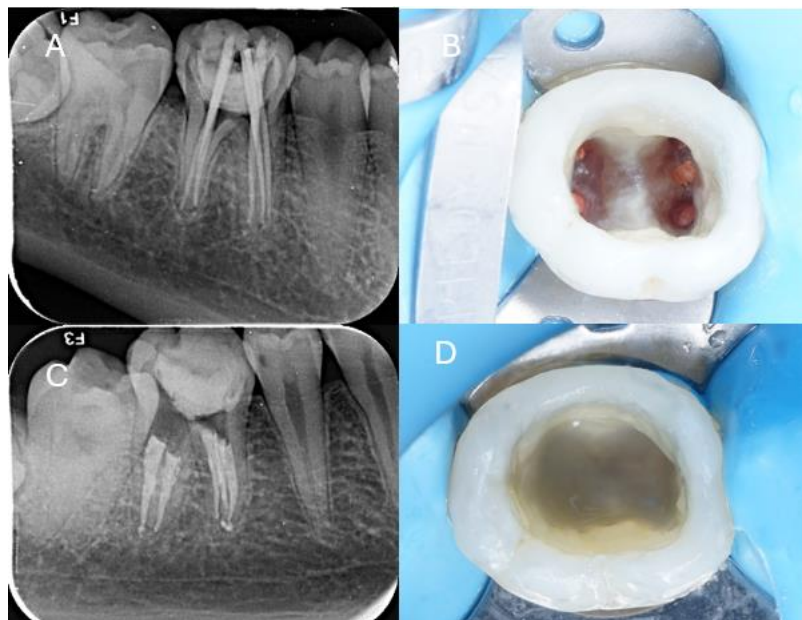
(A) Size 25 Reciproc gutta-percha cones were fitted, and periapical images using SLOB technique confirmed adaptation to the root canal shape and working length. (B) The cone was placed in the canal orifice, and vertical condensation toward the apex achieved a dense fill about 1–2 mm below the orifice using a heated endo plugger. (C) A postoperative periapical radiograph was obtained to assess the three-dimensional sealing of all canals, indicating obturation with no detected voids or overextension. (D) Smart Dentin Replacement (SDR, Dentsply Sirona, North Carolina, USA) was placed on the cavity floor.
